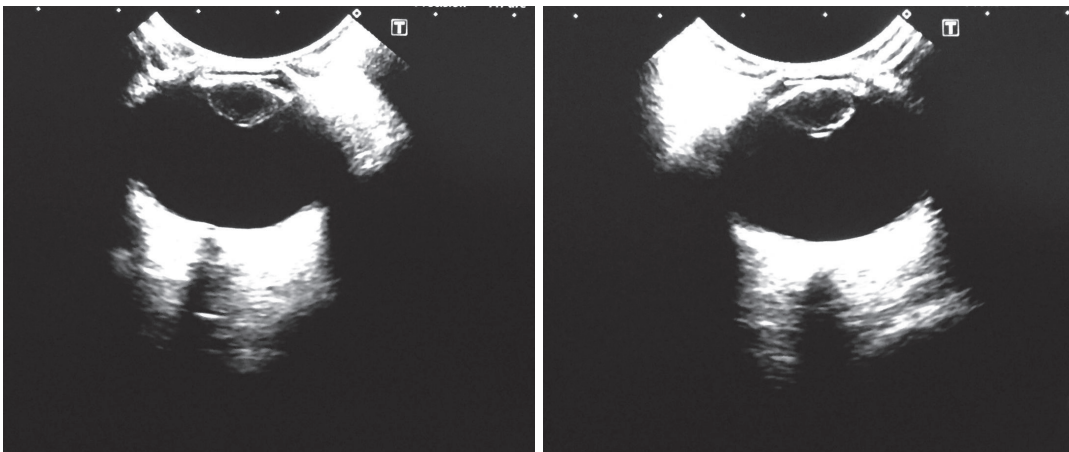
Ultrasonography in right and left eye.
